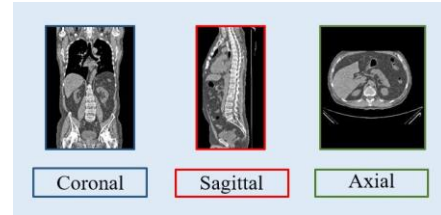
CT scan of the human torso as seen from different viewing directions. The coronal, sagittal, and axial image planes of the 3D volume are indicated as blue, red, and green squares around the CT scan.
